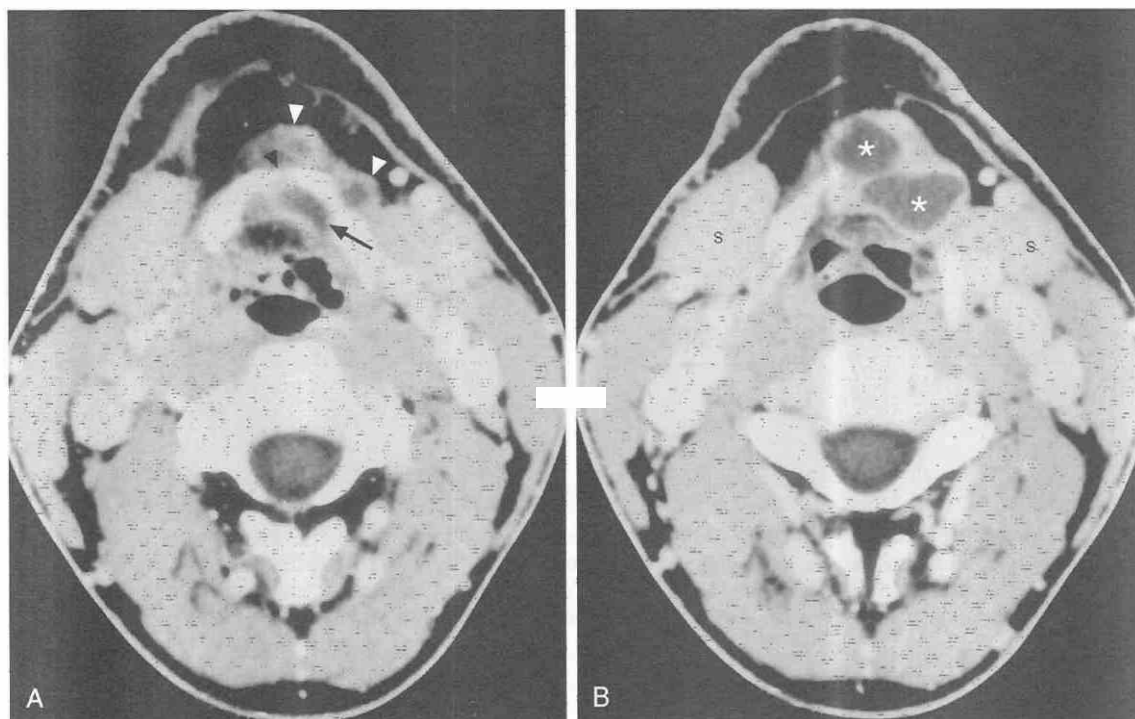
Thyroglossal duct cyst. *A*, Axial postcontrast CT scan at the level of the hyoid bone shows a multilobulated low-density mass traversing the hyoid bone. A component of the lesion is deep to the hyoid within the pre-epiglottic fat (arrow), and the remainder is seen anterior to the hyoid (white arrowheads). The bone defect can be seen within the central aspect of the hyoid bone (black arrowhead). Note also the submandibular glands (s). *B*, Axial CT scan in the same patient 5 mm caudal to *A* shows two low-attenuation components of the mass (asterisks) and their relationship to the hyoid bone. Submandibular glands are normal.
